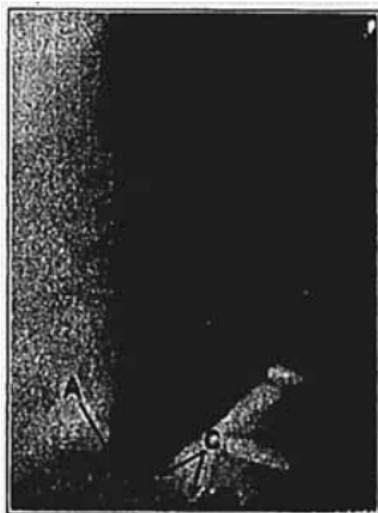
Lateral roentgenogram of bismuth meal retention in case of "cardiospasm." *A*, cardia, in contraction, without malformation, but with stenosis complete; *B*, diffusely dilated esophagus of rather marked degree, but contour normal; *C*, diaphragm line. (Roentgenogram by Joseph Johnson.)
